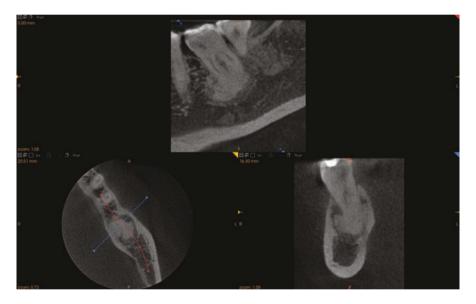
This small-field-of-view cone beam computed tomography scan of the first left-handside mandibular permanent molar with a cementoblastoma shows a uniform radiopaque mass attached to the mesial root. The lamina dura and the periodontal ligament space have disappeared and the mass extends towards buccal and lingual cortical plates of the mandible
